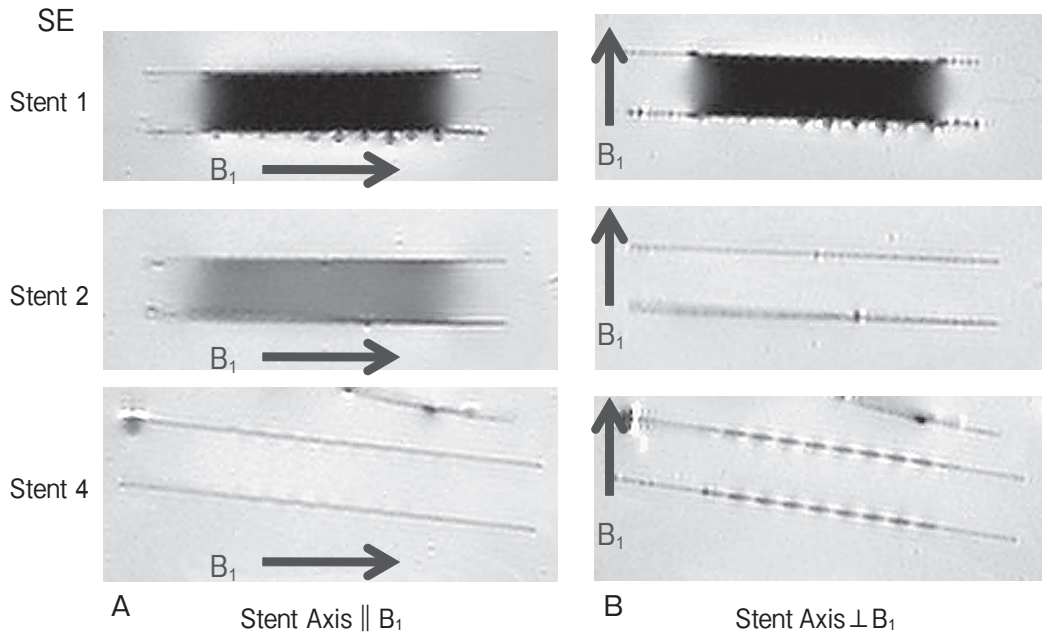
Sagittal SE MR images of Stent 1 (mesh pattern), Stent 2 (solenoid pattern), and Stent 4 (Moebius pattern). A, The stent axes are parallel to B₁; B, The stent axes are perpendicular to B₁.
